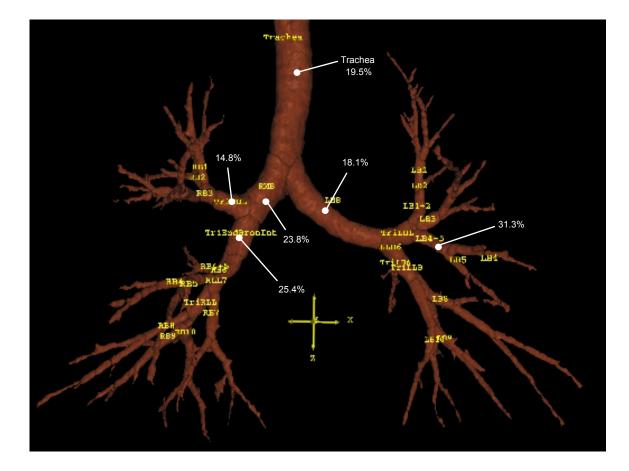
Three dimensional reconstruction of an airway tree using computed tomography.
